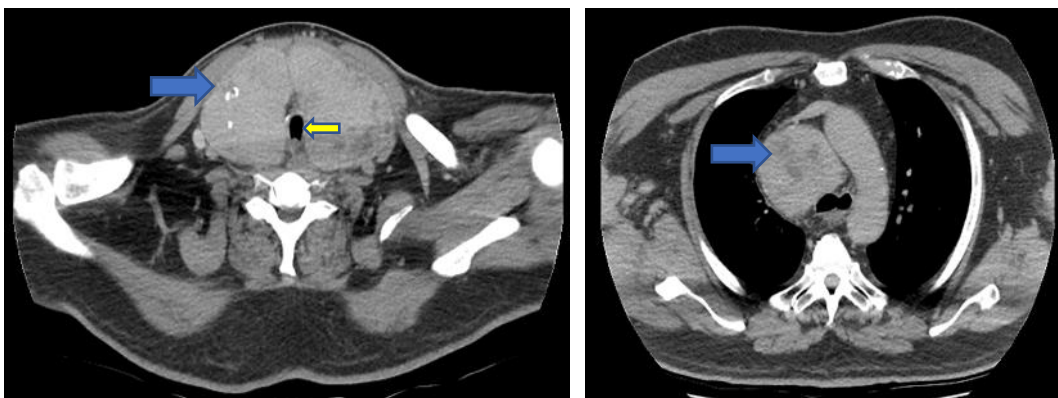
Retrosternal thyroid goitre (blue arrow). CT scans shows cervical thyroid is continuous with the mediastinal mass. Mass was surgical resected via a J-shaped partial sternotomy. The airway is compressed (yellow arrow)
